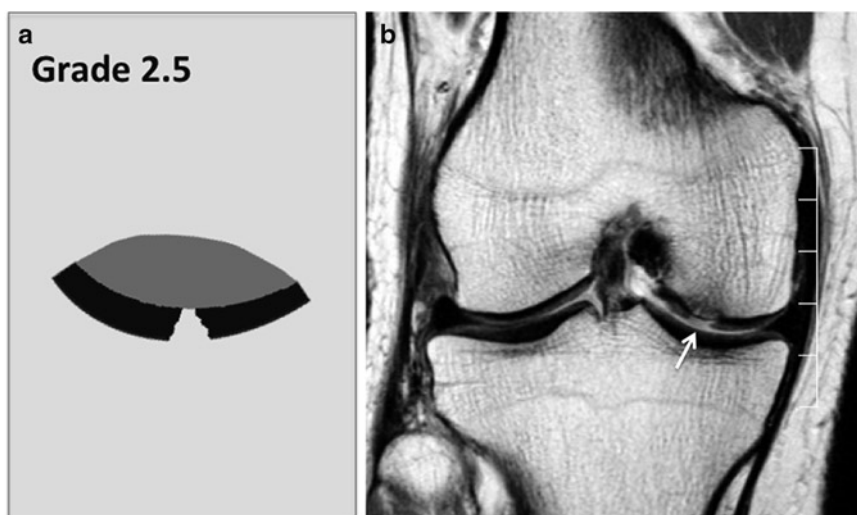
Whole-Organ-MRI-Score (WORMS) grade 2.5 lesion.* Graph of grade 2.5 knee cartilage lesion (a) and coronal proton density weighted fast spin echo sequence of the knee (b) showing a cartilage WORMS grade 2.5 lesion at the medial femoral condyle. The focal lesion measures less than 1 cm and extends to the subchondral
